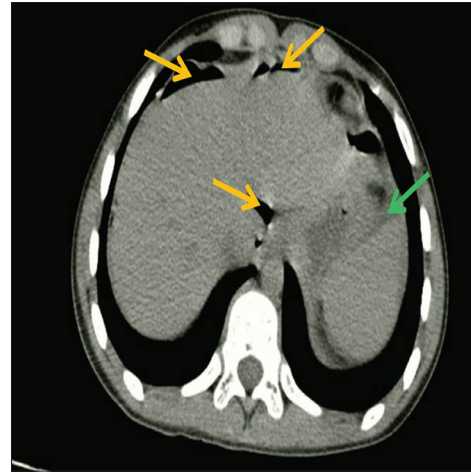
Axial non-contrast computed tomography of the abdomen showed several locules of free intra-peritoneal air within the upper abdomen, with a large amount of free air along the anterior aspect of the liver surface (yellow arrow) with peri-splenic ascites (green arrow). Normal appearance of the liver and spleen
